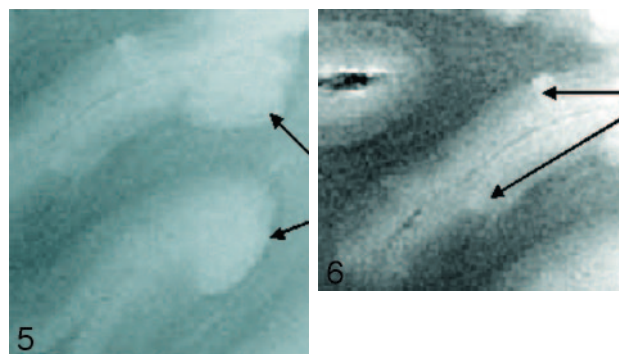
SE T2-weighted image, TR = 750 ms, TE = 20 ms, FOV = 15 cm, matrix = 1024 × 1024, section thickness = 1 mm. Type 5 cortical lesions (arrows). Lesion extends from all layers of the cortex to the adjacent white matter. The adjacent white-matter involvement distinguishes these lesions from type 2 lesions, which are restricted to the layers of the cortex only.
